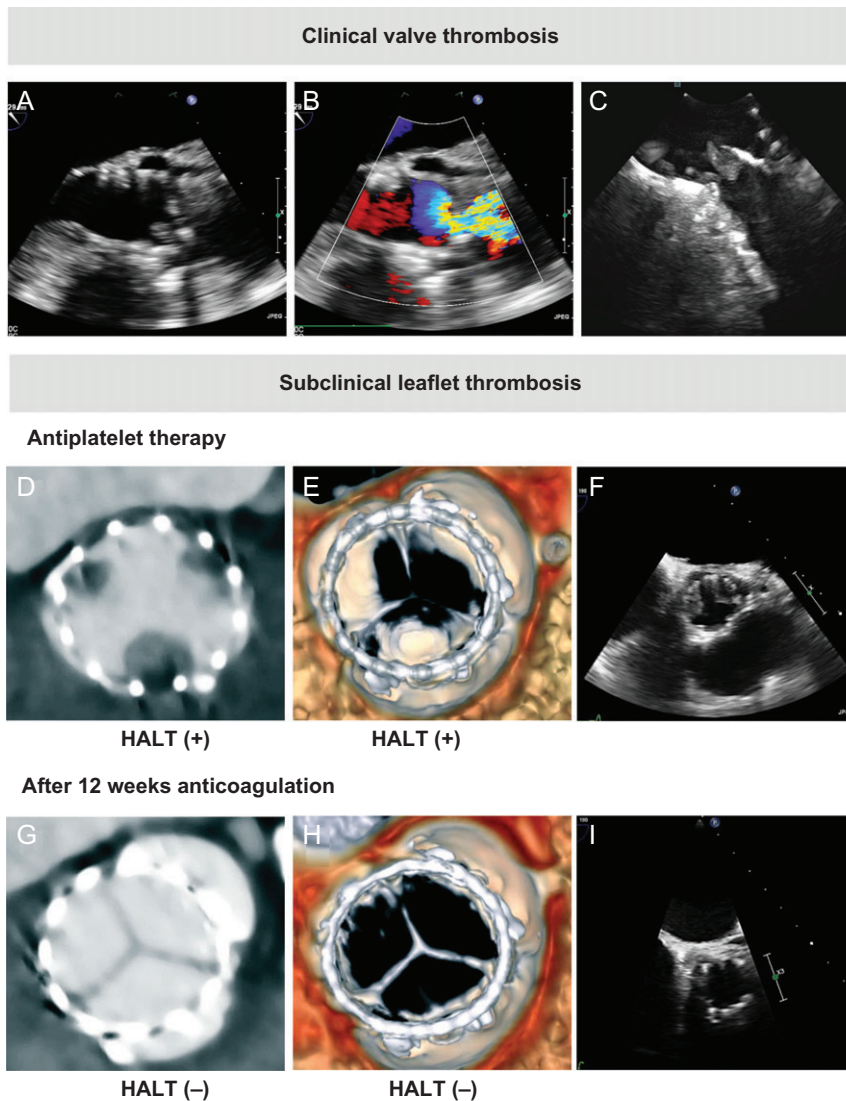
Clinical valve thrombosis and subclinical leaflet thrombosis. (A, B) Transesophageal echocardiography (TEE) showing valve thrombosis and turbulent color flow over the transcatheter aortic bioprosthesis in a patient presenting with an elevated mean transvalvular gradient at transthoracic echocardiography (TTE, 37 mmHg) and dyspnea NYHA class 3-4, a few years after TAVR. (C) Thrombotic mass at the aortic side of the prosthetic leaflets was confirmed by intracardiac echocardiography (ICE). (D, E) Incidental finding of hypoattenuating leaflet thickening (HALT) at the base of the transcatheter heart valve leaflets, with hypoattenuation affecting motion (HAM) visible in systole in the volume-rendered 4D computed tomography (4DCT) images; (F) this reduced leaflet motion of two leaflets was confirmed by TEE. (G, I) Resolution of the leaflet thickening and reduced leaflet motion following 3 months of anticoagulation treatment, as shown by 4DCT and TEE imaging.
